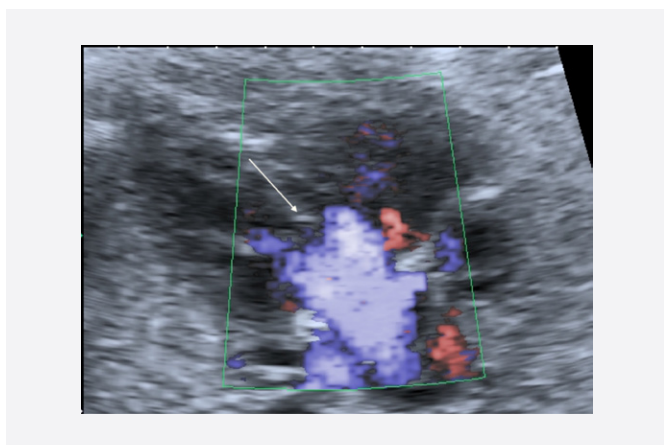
Color flow Doppler: blood flow from the left and right ventricles into the dilated and displaced aorta (arrow)
